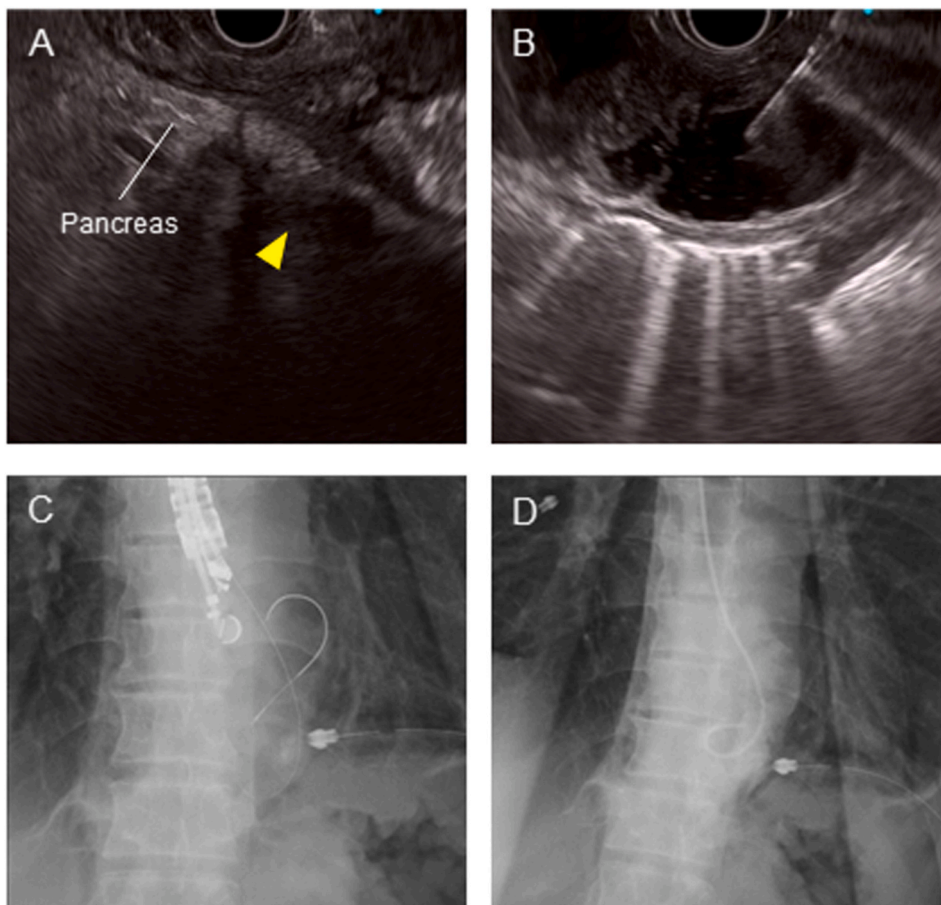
EUS-guided transesophageal drainage of acute mediastinitis. We confirmed the remaining trace of pancreatic fistula from the tail of the pancreas (*arrowhead*) (A). The accumulated mediastinal fluid was drained from the lower esophagus (B) under EUS guidance. A guidewire was inserted through the puncture needle (C) and an endoscopic nasocystic drainage tube placed (D).
